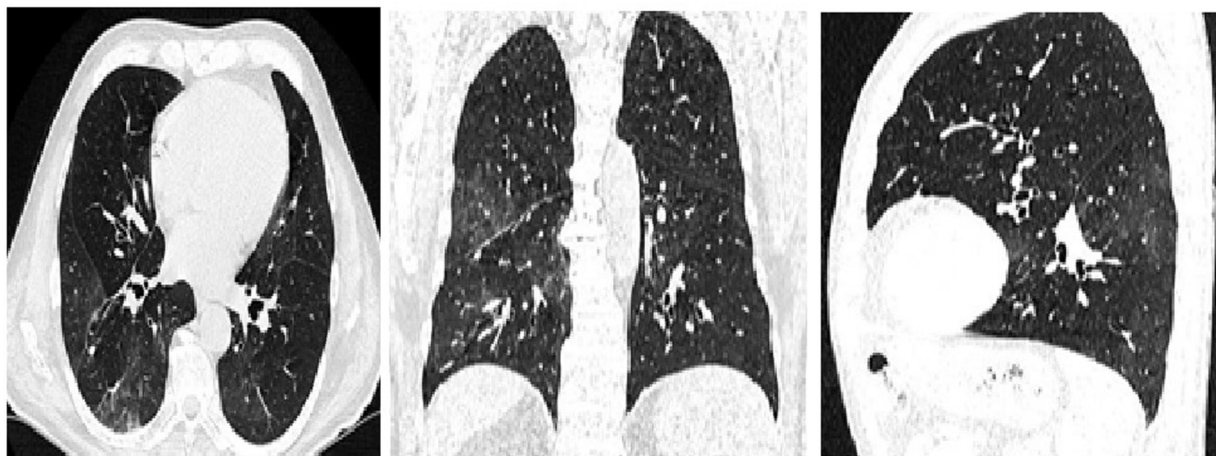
CT chest prior to surgery.
